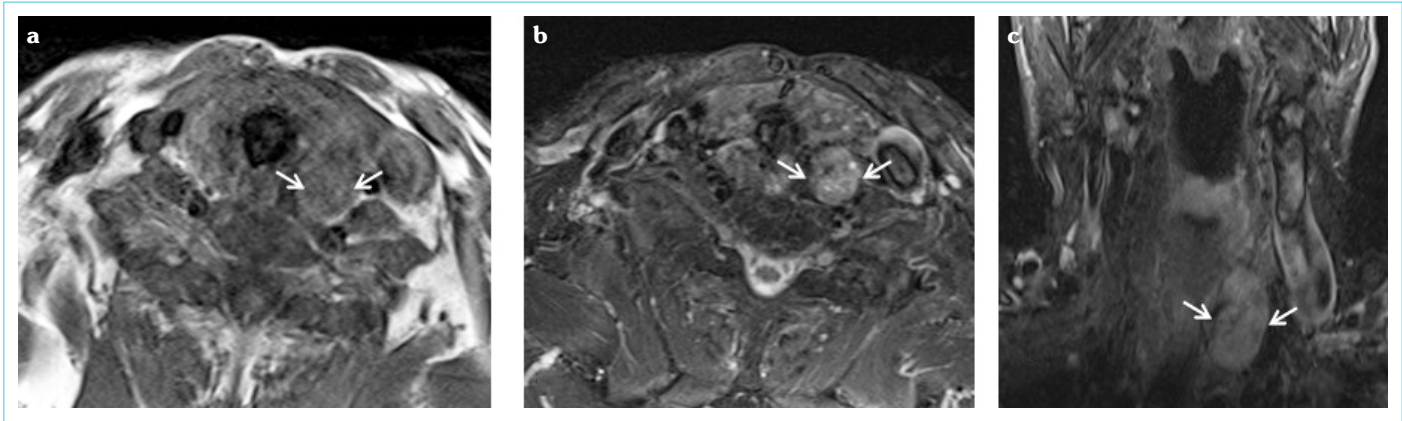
Axial (a, b) and coronal (c) MRI images show T1 iso-hypointense, T2 heterogeneous, hyperintense nodular lesion posterior to the left lobe of the thyroid consistent with parathyroid adenoma (arrows)
